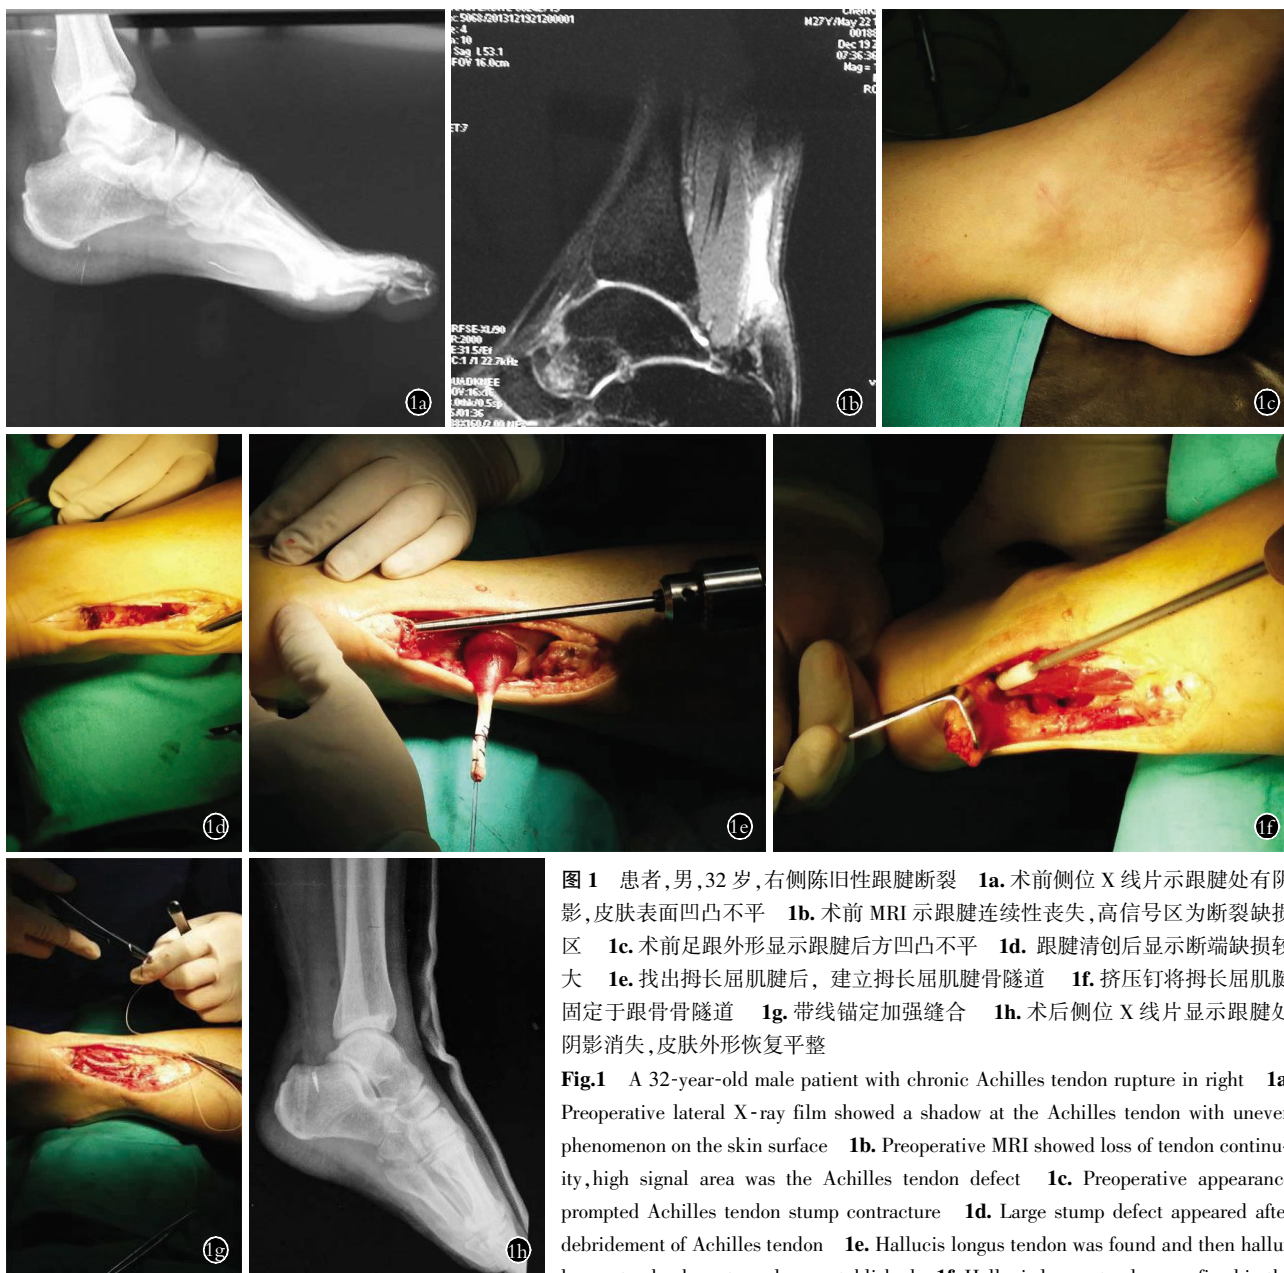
患者,男,32 岁,右侧陈旧性跟腱断裂 1a. 术前侧位 X 线片示跟腱处有阴影,皮肤表面凹凸不平 1b. 术前 MRI 示跟腱连续性丧失,高信号区为断裂缺损区 1c. 术前足跟外形显示跟腱后方凹凸不平 1d. 跟腱清创后显示断端缺损较大 1e. 找出拇长屈肌腱后,建立拇长屈肌腱骨隧道 1f. 挤压钉将拇长屈肌腱固定于跟骨骨隧道 1g. 带线锚定加强缝合 1h. 术后侧位 X 线片显示跟腱处阴影消失,皮肤外形恢复平整
